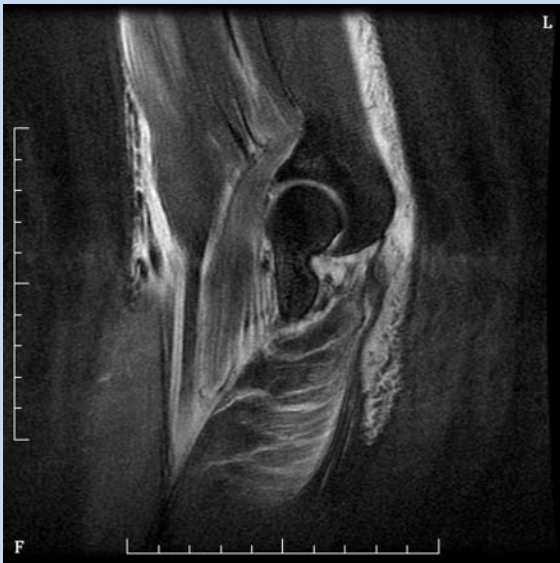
Sagittal view of T2-weighted MRI showing triceps tendon disruption.
